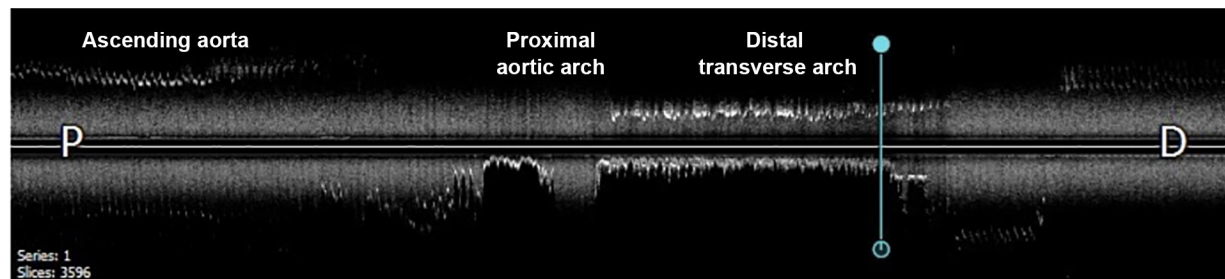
Intravascular ultrasonogram obtained during pullback from the ascending aorta to the descending thoracic aorta reveals a dense, linear calcified mass protruding into the aortic lumen. The minimal luminal diameter is 6 mm at the vertical blue marker line.
